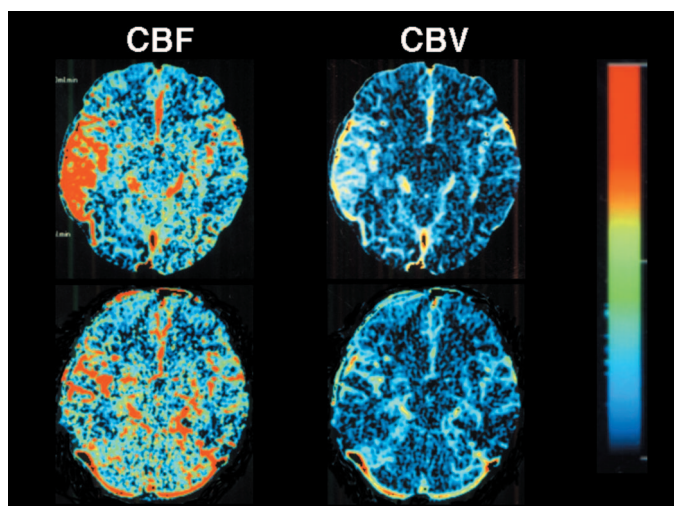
Perfusion CT images 7 hours after the onset of headache and agitated delirium showing increased CBF and cerebral blood volume in the right temporal lobe (top row). The CBF was twice as high in the right temporal lobe (76 ml/100 g/min) as in the left temporal lobe (34 ml/100 g/min). Repeated perfusion CT images 15 days after the onset of the symptoms show resolution of hyperperfusion in the right temporal lobe (bottom row).
